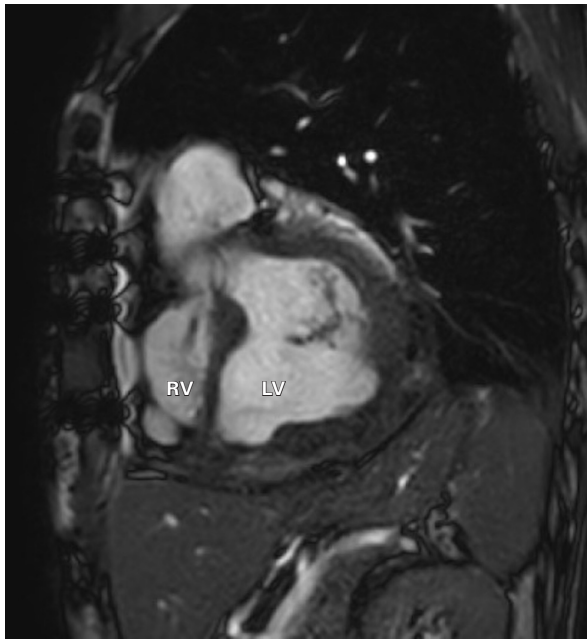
Cardiac magnetic resonance image shows successful left ventricular pseudoaneurysm repair without leakage through the patch.
